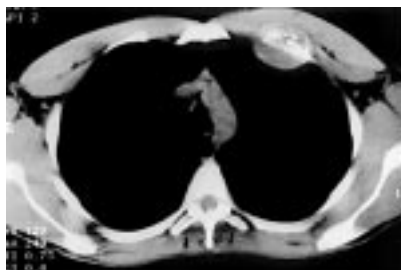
Computed tomographic scan of the chest showing a mass in the left anterior chest wall.
